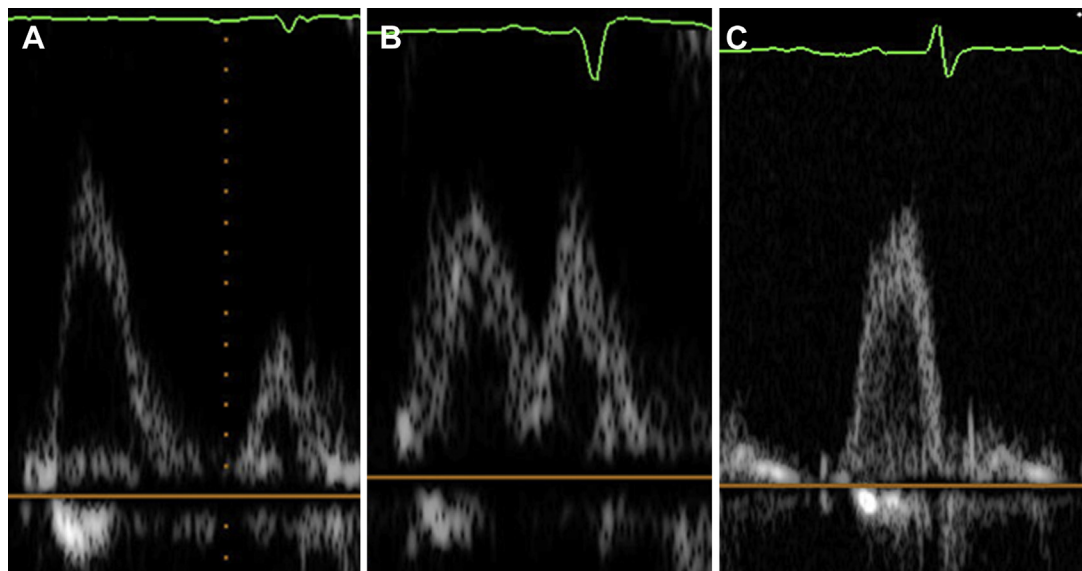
AVV Doppler E- and A-wave fusion: (A) nonfused E and A waves; (B) partial fusion of E and A waves; (C) complete fusion of E and A waves.
